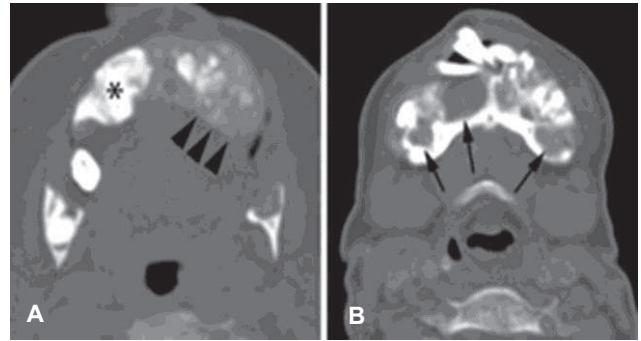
Cross-sectional CT of the mandible in bone algorithm at the level of the mandibular angles (A) and symphysis menti (B). There is a loss of cortical and marrow differentiation. This has been replaced by a ground glass density, with areas of irregular osseous expansion (*arrowheads in A*) and patchy regions of osteosclerosis (*asterisk in A*). Cystic lesions with well-circumscribed sclerotic margins (*arrows in B*) are likely Brown tumours, with evident dental displacement.
